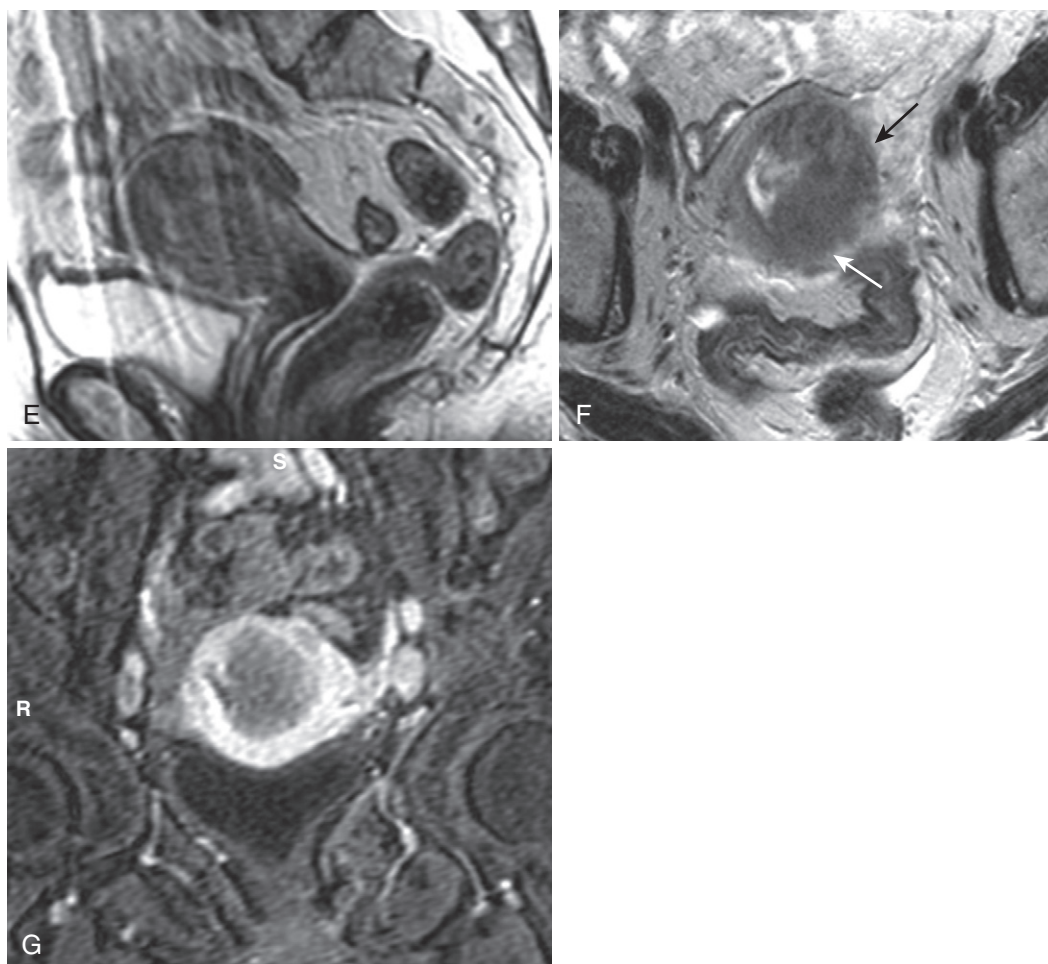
cont'd Sagittal T2-weighted image (E) in a different patient degraded by motion artifact poorly depicts uterine zonal anatomy, which is seen to be due to an infiltrative mass on the axial image (arrows in F). G, Coronal enhanced image demonstrates deep invasion of the enhanced myometrium by the hypovascular mass.
